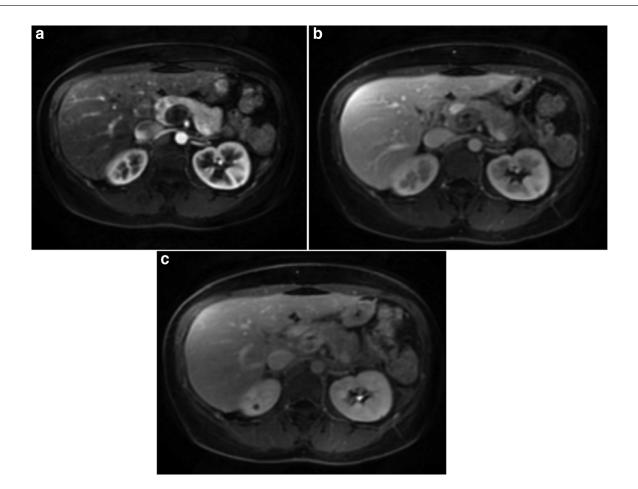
Following administration of intravenous contrast, axial MRI images were acquired during arterial, portal venous and 5-minute delayed phases (left to right). These images demonstrate progressive, delayed heterogeneous enhancement of the pancreatic neck mass.
